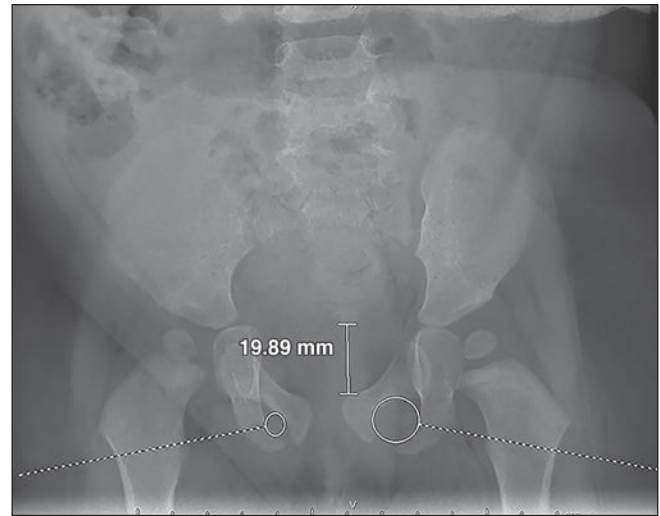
9-month-old healthy girl with developmental dysplasia of left hip. Anteroposterior pelvic radiograph is poor-quality image. Coccyx appears rotated compared with pubic symphysis. Obturator foramen and iliac wings are asymmetric (circles, dashed lines). Distance between inferior tip of coccyx and pubic symphysis (solid line) does meet criterion.
